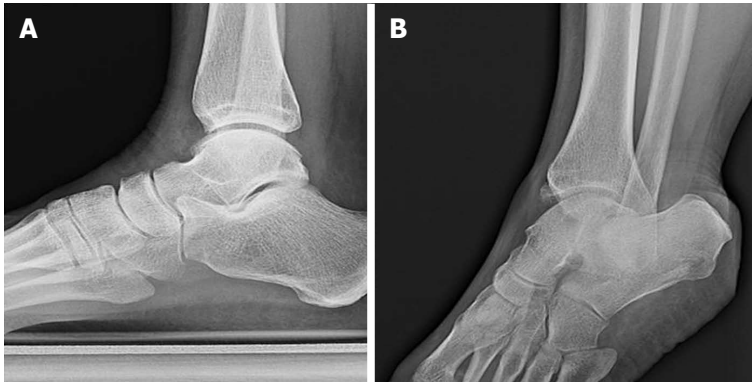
Standard lateral views about anterior tibial osteophytes. Lateral plain radiograph of a right ankle with clinical suspicion of anteromedial impingement (A). An anteromedial radiographic view with 30 degrees of external rotation of the same ankle demonstrated an osteophyte on the anteromedial aspect of the distal tibia (B) that could not be appreciated on the lateral view.
